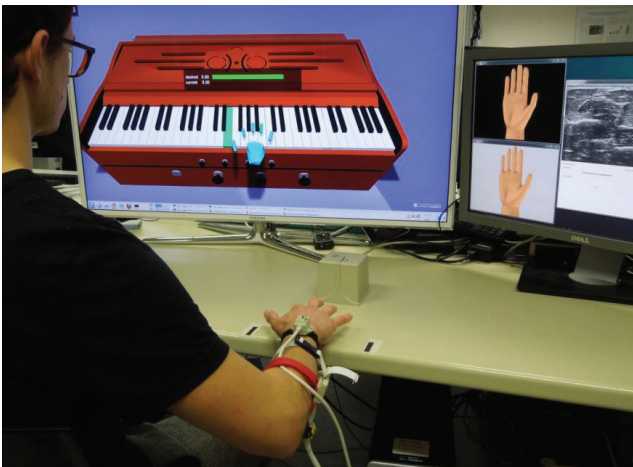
The Ultraharmonium setup: playing a virtual keyboard instrument using ultrasound images of the forearm (reprint from [1]).
